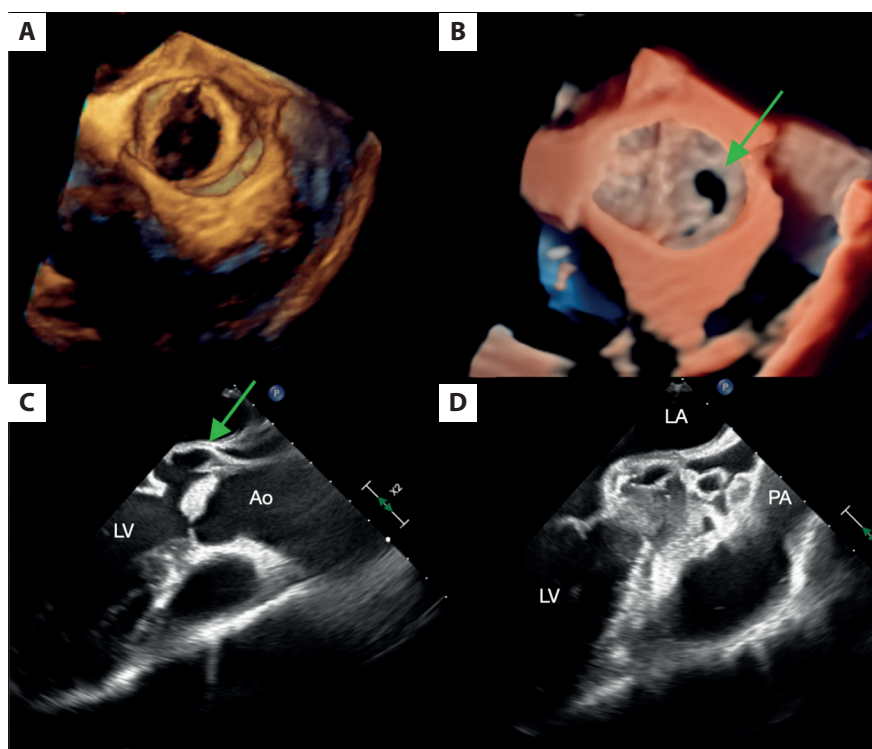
Echocardiography examination. A. Bicuspid aortic valve in 3D Echo. B. Perforation of fused leaflet of the aortic valve (arrow). C. Pseudoaneurysm of mitro-aortic continuity (arrow). D. Abscess penetrating toward pulmonary artery
